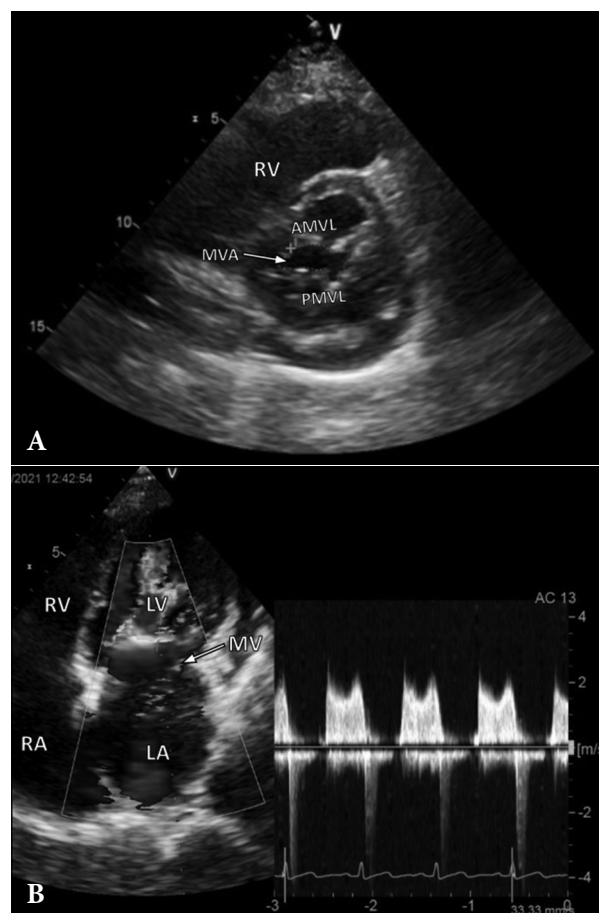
Transthoracic echocardiography on admission: A) mitral valve stenosis from parasternal short-axis view; B) transmitral flow with continuous wave Doppler, maximal gradient 24 mmHg, mean gradient 13 mmHg
